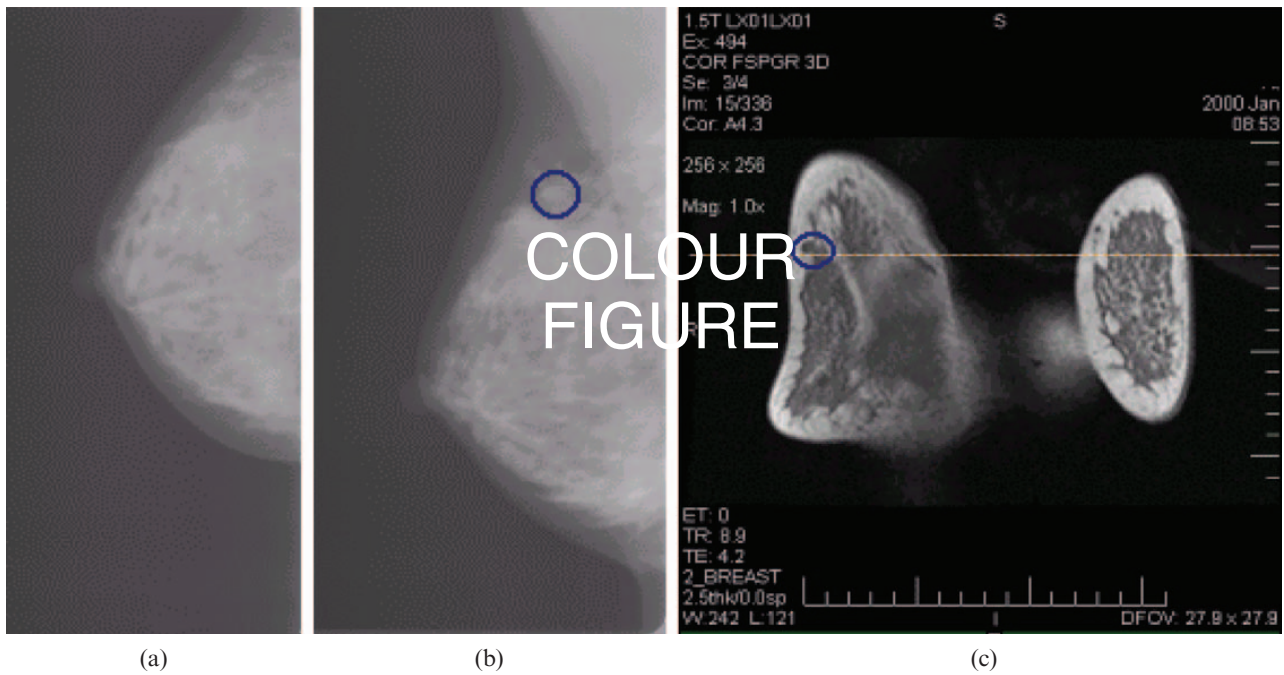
Initial assessment of the mammograms with the suspected region of interest highlighted by the clinician in the lateral mammogram (b) along with a corresponding region in a slice of the contrast-enhanced MRI volume (c). No lesion was obviously apparent in the cranial–caudal mammogram (a).
